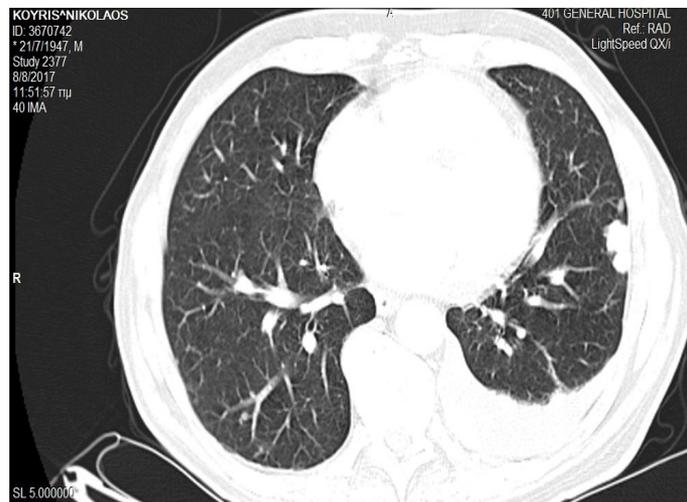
A baseline chest CT scan showing multiple bilateral lung lesions and a left pleural effusion.
